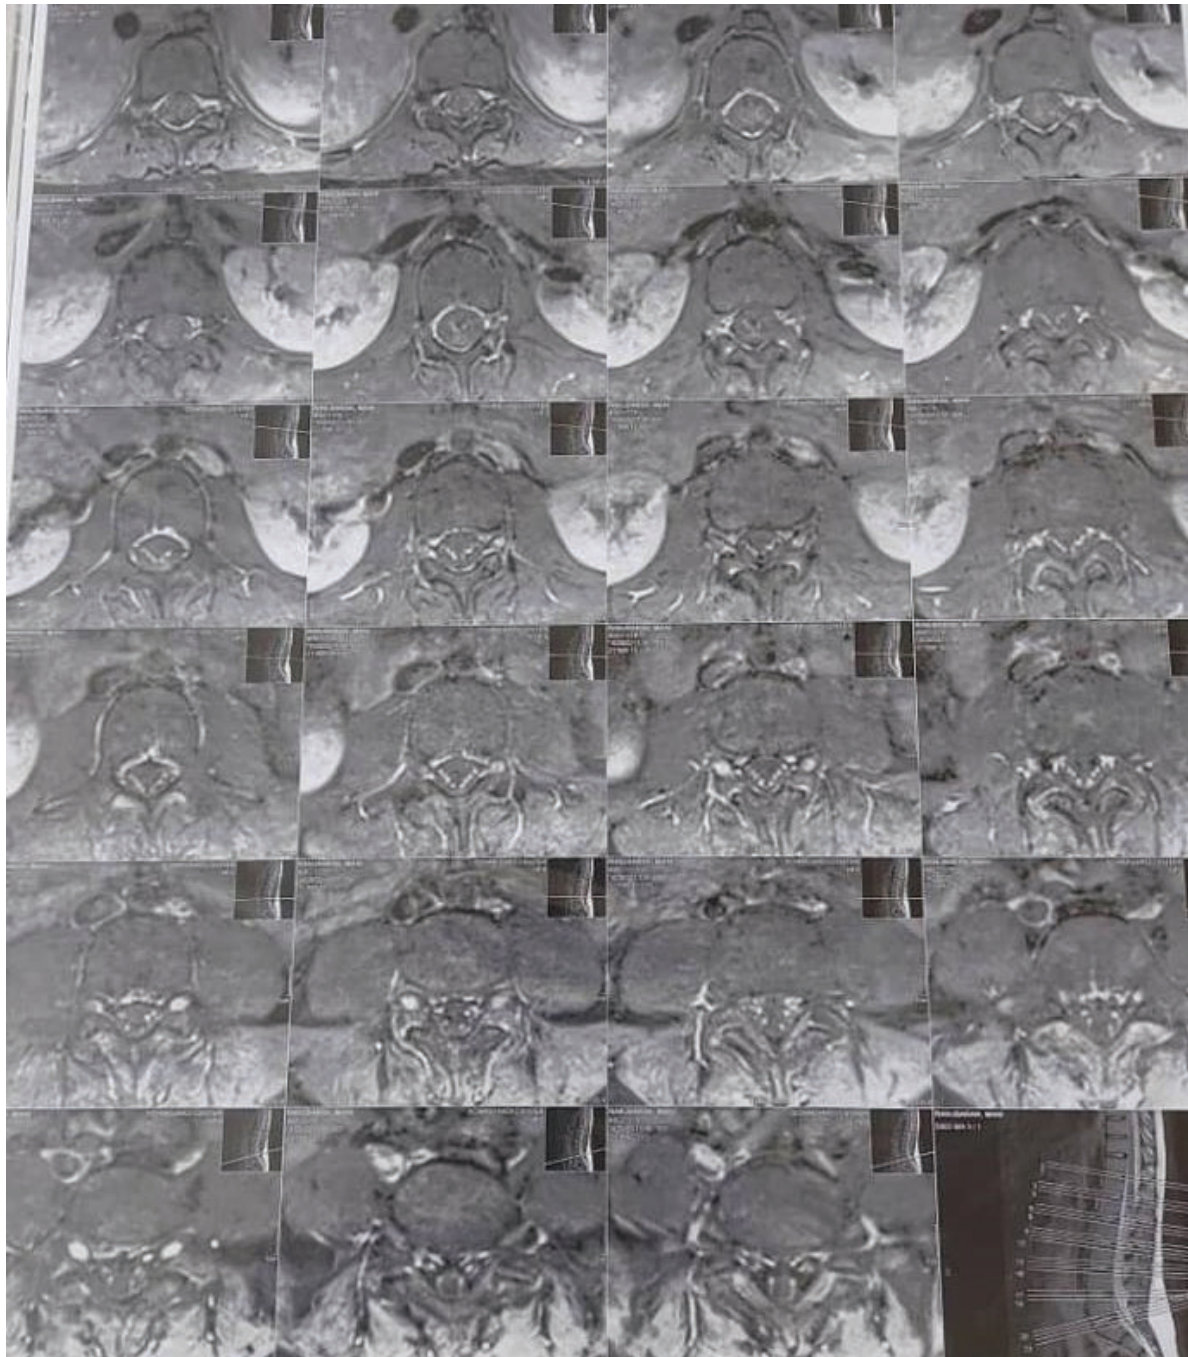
Lumbosacral MRI – axial view
